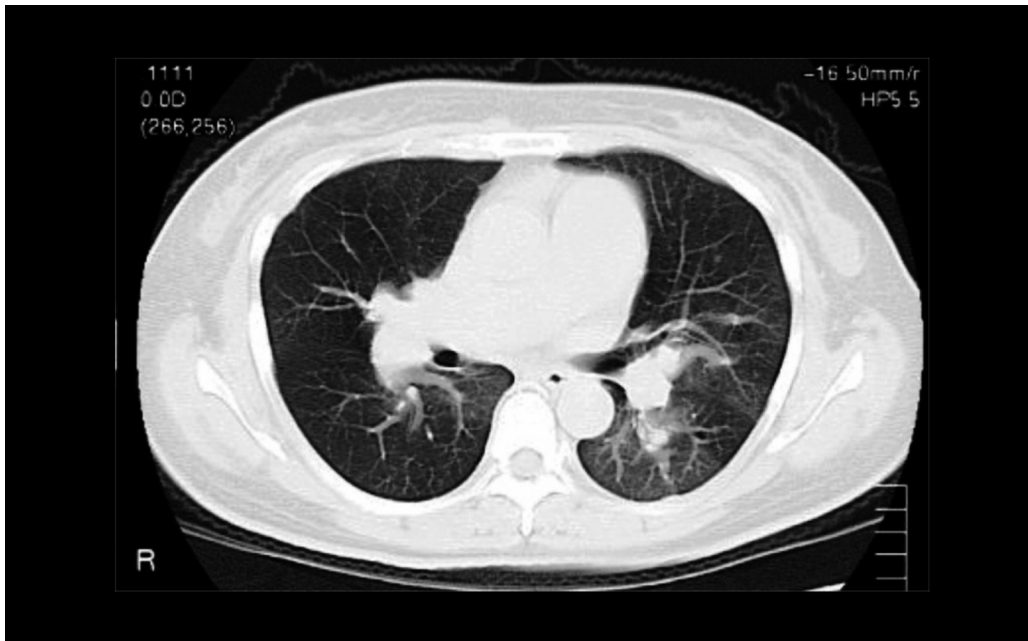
Plain CT image of the lung field in a patient with CTEPH
